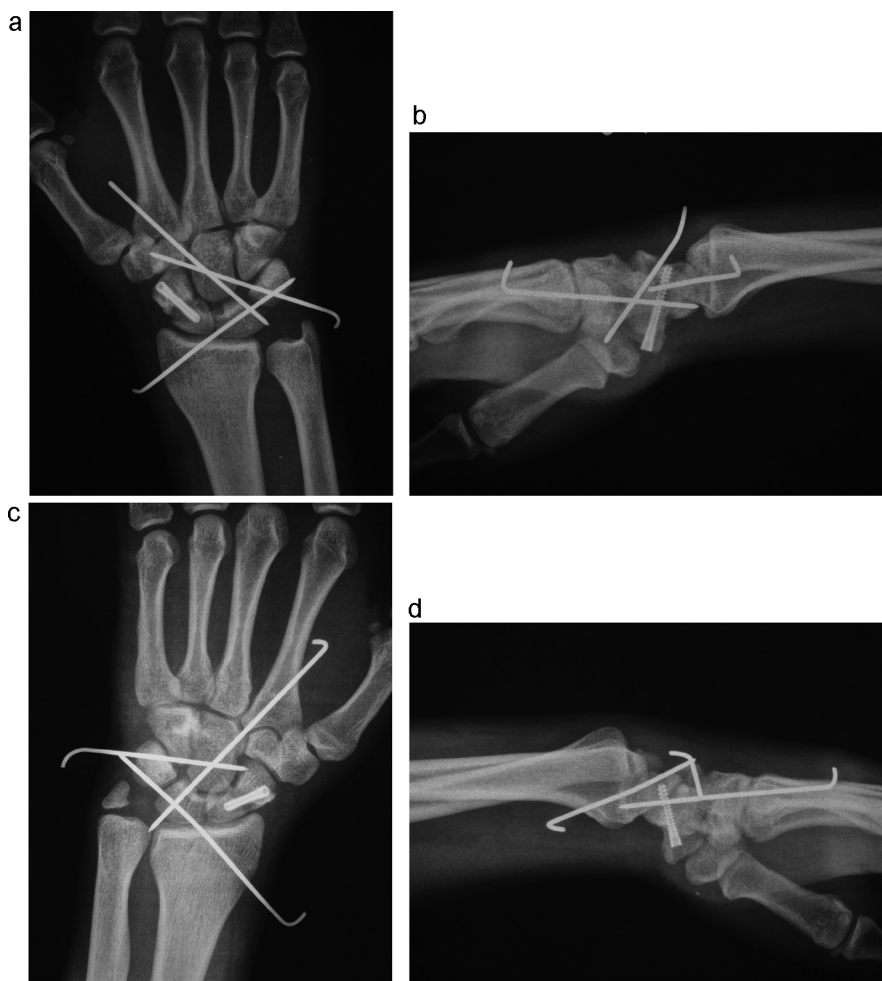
Right wrist. (a) Anteroposterior and (b) lateral view immediately after anatomic reduction, stabilization of the carpus with K-wires and fixation of the scaphoid fracture. Left wrist. (c) Anteroposterior and (d) lateral radiographs showing the same appearance as (a) and (b).
